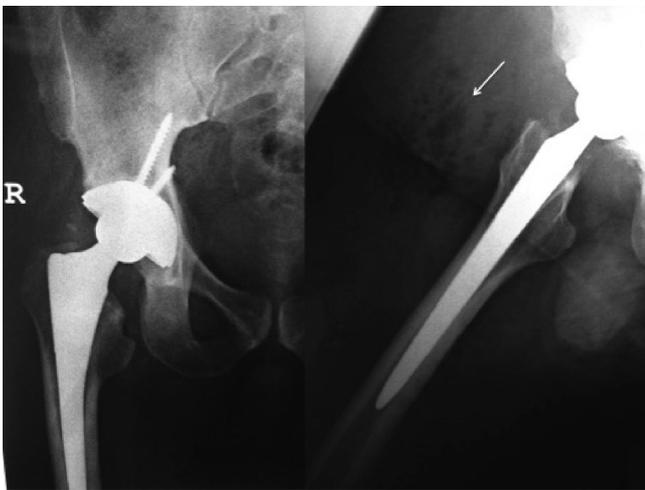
Plain radiographs of the replaced hip. Subcutaneous emphysema is present (arrow), but there are no radiolucent lines around the femoral stem or acetabular shell.
